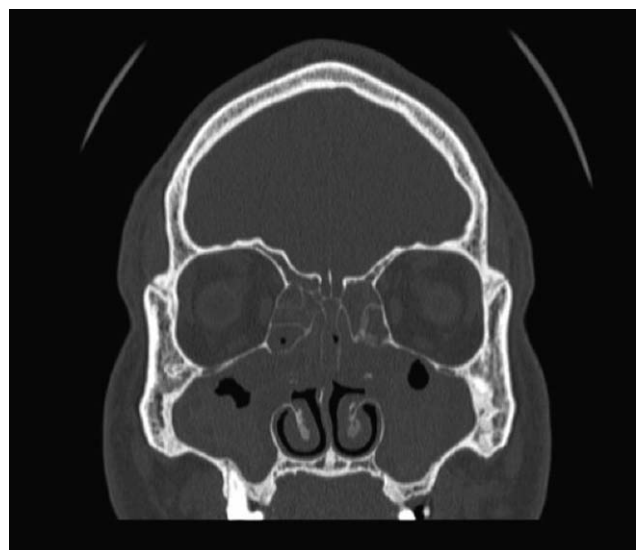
Coronal computed tomography of the sinus demonstrating pansinusitis with near-complete opacification of all the sinuses.
